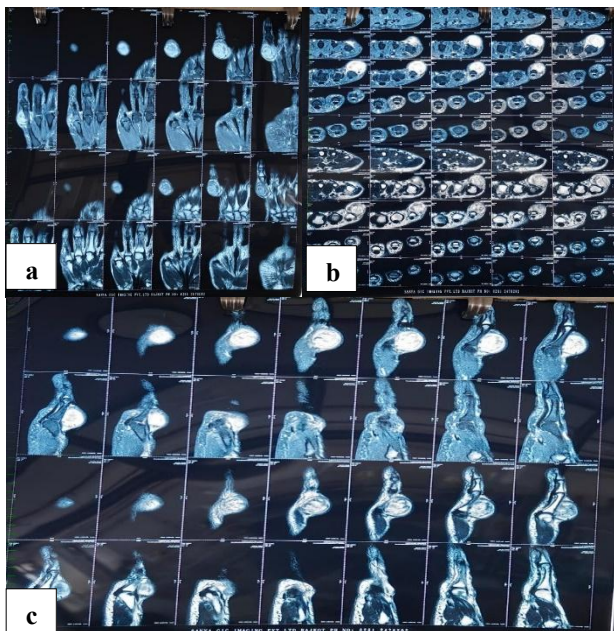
(a-c): MRI findings showing well defined heterogeneous soft tissue lesion.
